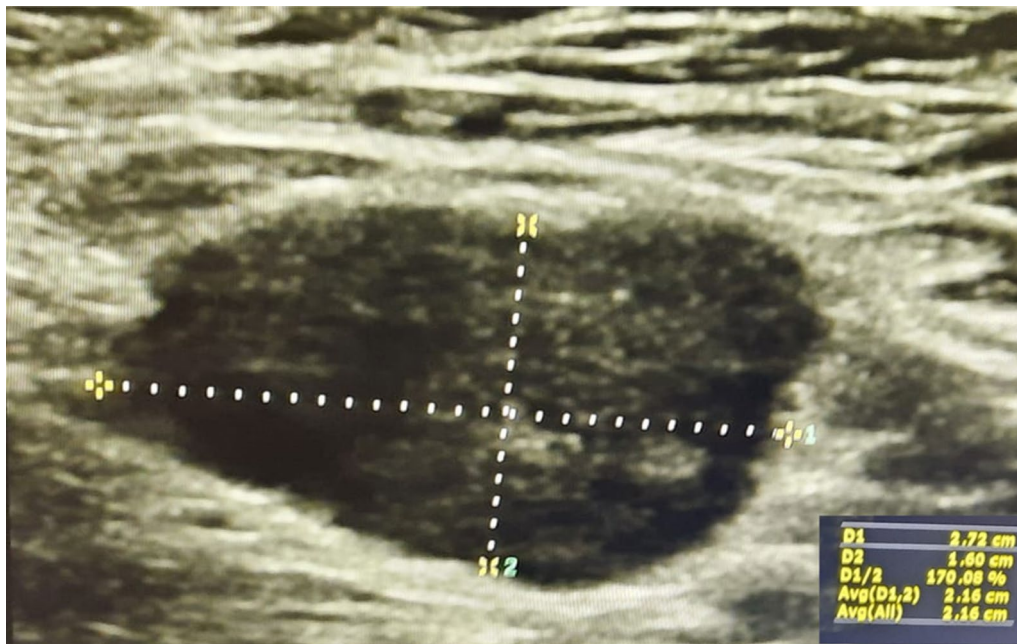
Ultrasound from the left breast lower inner quadrant shows a well-defined, lobulated 2.72 × 1.60 cm hypo-anechoic lesion with internal debris. No vascularity was appreciated within or surrounding the lesion. No e/o calcification/septations or solid component seen within (BIRADS 3)
